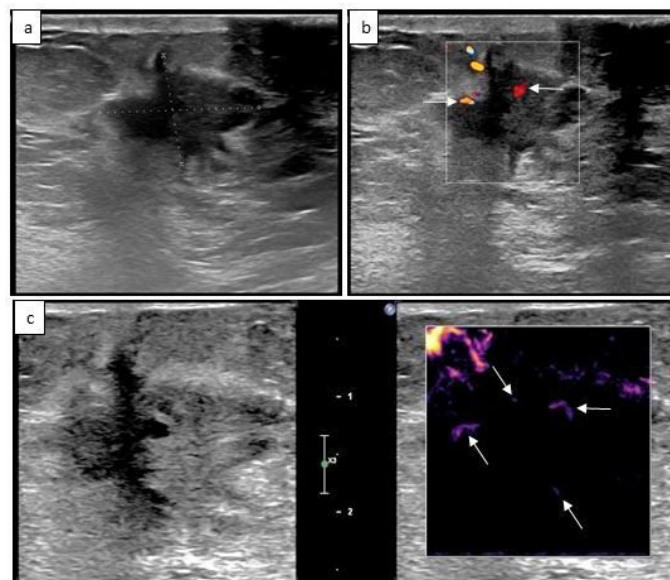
A 36-year-old female patient's ill-defined lesion in the upper inner quadrant of the right breast, with occasionally angled edges, was evaluated as BI-RADS 4 (a). Pathological diagnosis was reported as benign phyllodes tumor. No significant vascularization was detected in the patient's color Doppler (b) and power Doppler (c) ultrasonography examinations, while microflow imaging (d) shows 3 point vascular structures in the lesion (arrows).
